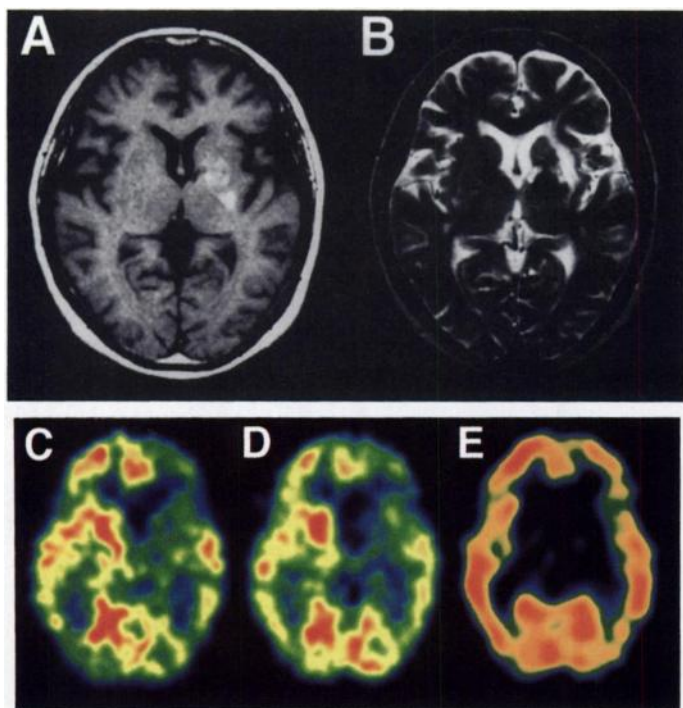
Patient 2, a 64-yr-old woman with cerebral infarction in the left basal ganglia. (A) T1-weighted MR image; (B) T2-weighted MR image; (C) CBF-PET; (D) CMRO₂; (E) ¹²³I-IMZ SPECT, all obtained 50 mm above and parallel to the OM line. MR images demonstrate an infarct in the left basal ganglia and left internal capsule. A perfusion defect, reduced CMRO₂ and reduced uptake of ¹²³I-IMZ are observed in the lesion. The left frontal lobe is diagnosed as a remote deafferentated area because of a decreased CBF and decreased CMRO₂ with minimal cortical atrophy on MR images. The change in ¹²³I-IMZ uptake was minimal in the remote deafferentated area.
